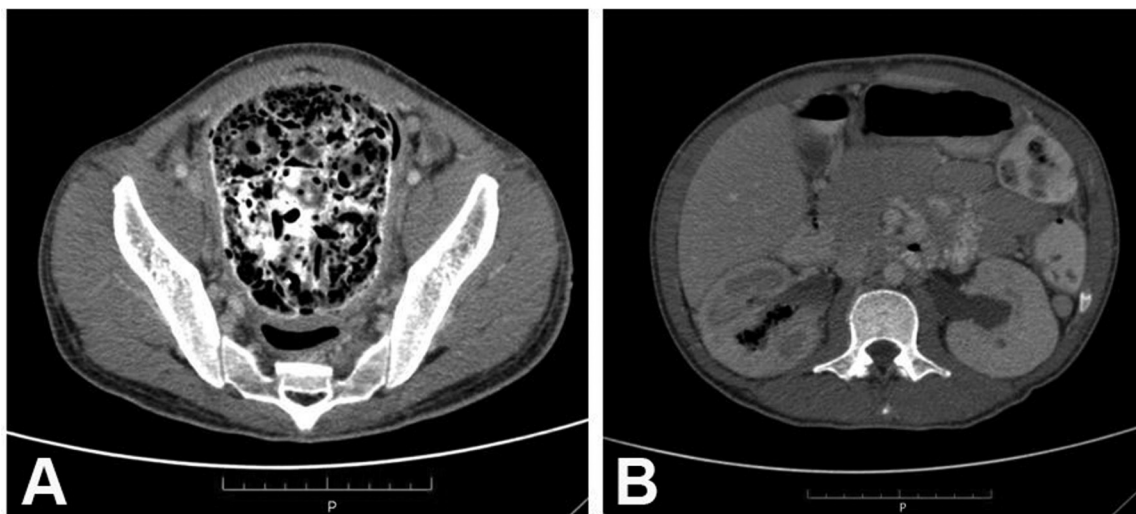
A) CT scan showing the urinary bladder filled with mottled soft tissue densities and air pockets; B) CT scan showing bilateral pelvocaliectasia and an emphysematous right renal pelvis.
